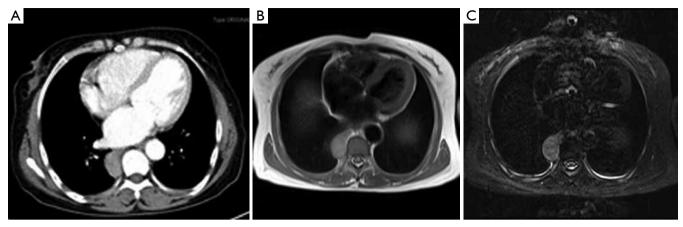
(A) An enhanced chest CT scan revealed a posterior mediastinal mass, which could be partially enhanced; (B,C) MRI demonstrated that the mass extended from the paravertebral region and was moderately intensified in T1-weighted image. CT, computed tomography; MRI, magnetic resonance imaging.
